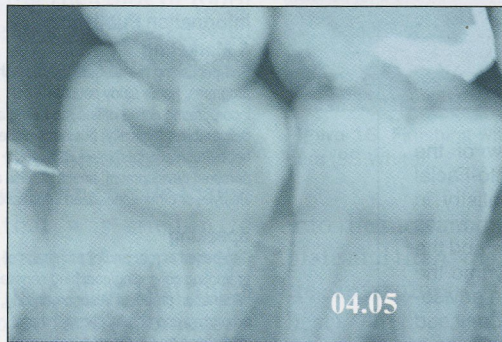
A patient presented with a large asymptomatic lesion that showed extensive caries radiographically.
